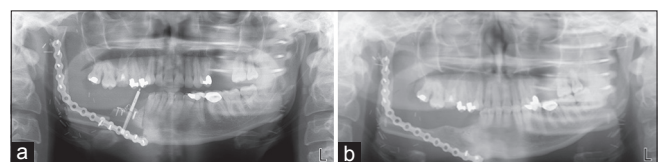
(a and b) Orthopantomograph of the same patient demonstrating vertical bone gain of 9 mm
